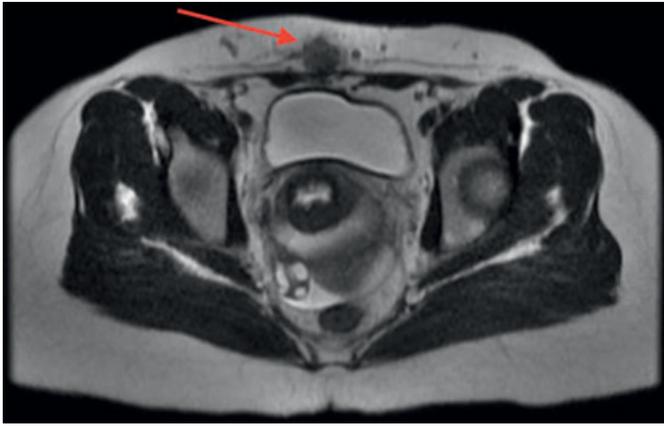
Magnetic resonance image transverse view of pelvis demonstrating endometrioma in cesarean incision.
